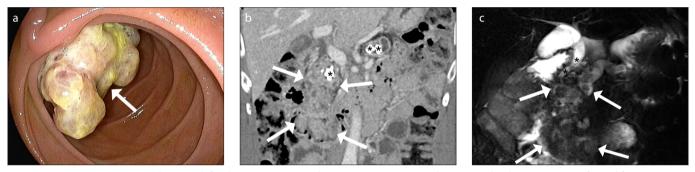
a–c. Case 5, a 53-year-old-man with focal pancreatic ITPN with invasive carcinoma. Esophagogastroduodenoscopy (a) performed for routine screening shows a large polypoid mass (*arrow*) in the duodenal 2nd portion. Coronal reconstructed contrast-enhanced portal phase CT image (b) shows a large polypoid isoattenuating mass (*arrows*) replacing the main pancreatic duct in the pancreas head with extension to the lumen of the duodenal 2nd portion. Several pancreatoliths (*asterisks*) are also intermingled with the mass or located in the markedly dilated distal pancreatic duct. Three-dimensional MRCP image (c) shows a large polypoid filling defect (*arrows*) along the dilated main pancreatic duct in the pancreas head and duodenal 2nd portion as well as displaced extrahepatic bile duct (*asterisks*).
